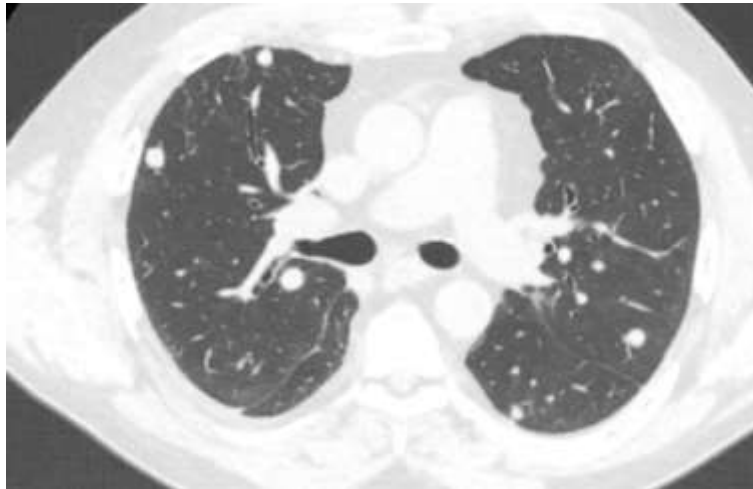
Representative image in lung windows from the repeat thoracic CT scan.
